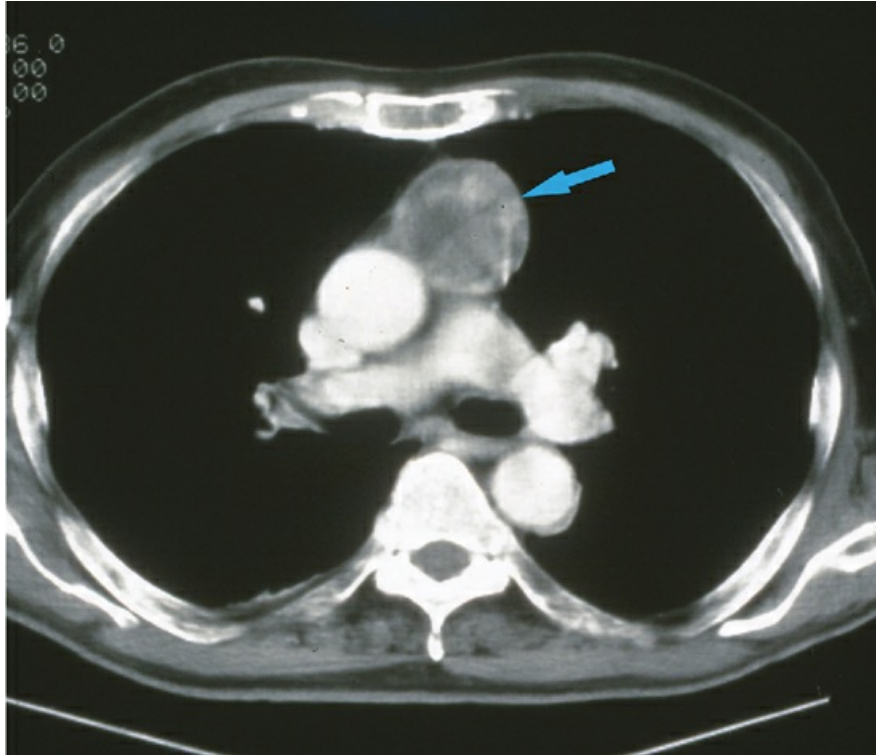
Contrast-enhanced chest computed tomography scan showing an anterior mediastinal mass due to a cystic thymoma (arrow). *Source:* (Courtesy of Dr. Paul Stark.)
